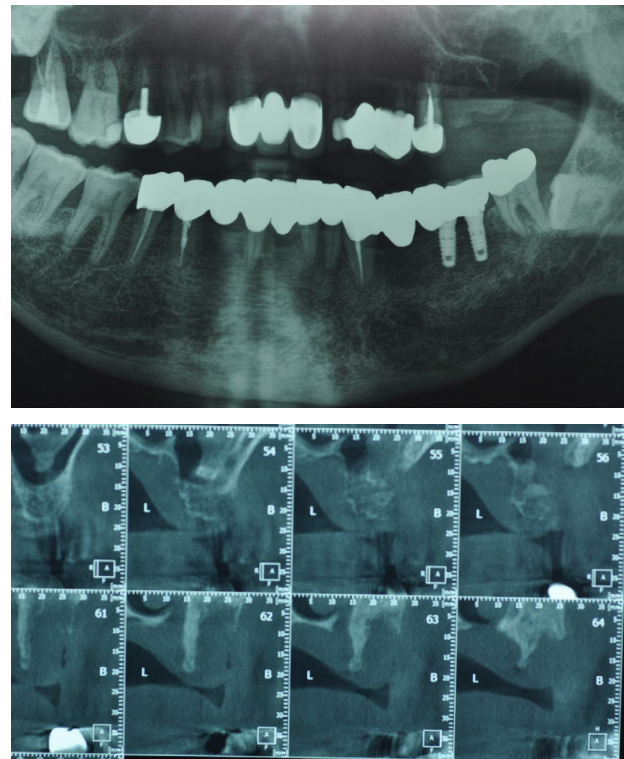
X-rays demonstrating successful bone healing.
